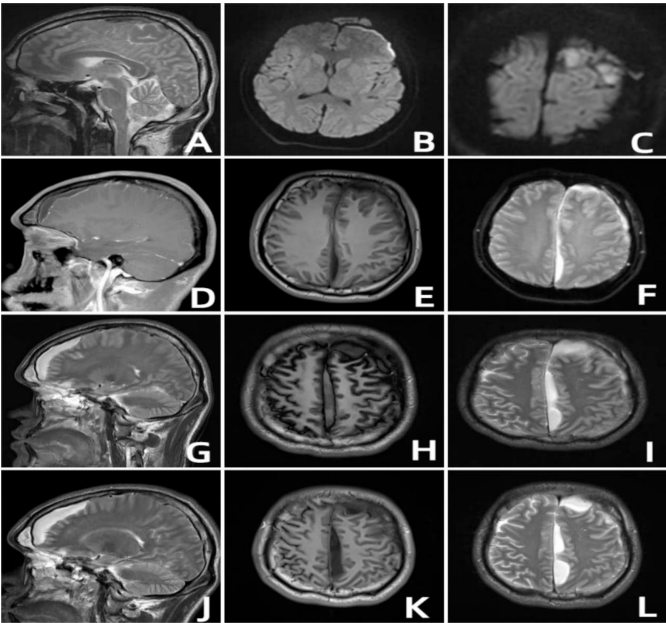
d1 MRI; T2 (A), T 2 (B), DWI (C); d6 MRI; enhanced T1 enhancement (D), T1 (E), T2 (F); d9 MRI; enhanced T2 (G), T1 (H), T2 (I); d19 head MRI; T2 (J), T1 (K), T2 (L).
